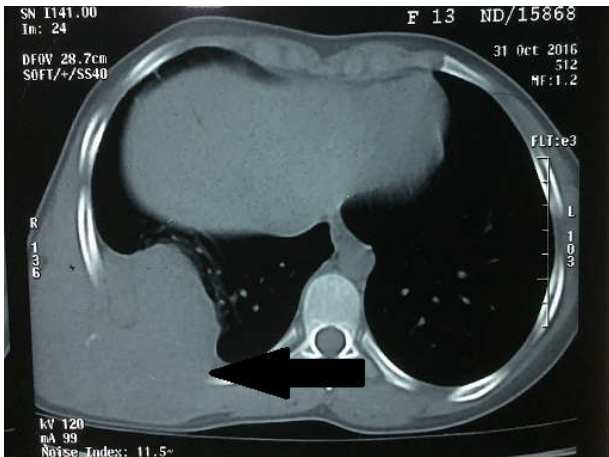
CT scan of the patient revealed a SOL measuring 20×20×15 cms arising from right chest wall (marked with arrow).
